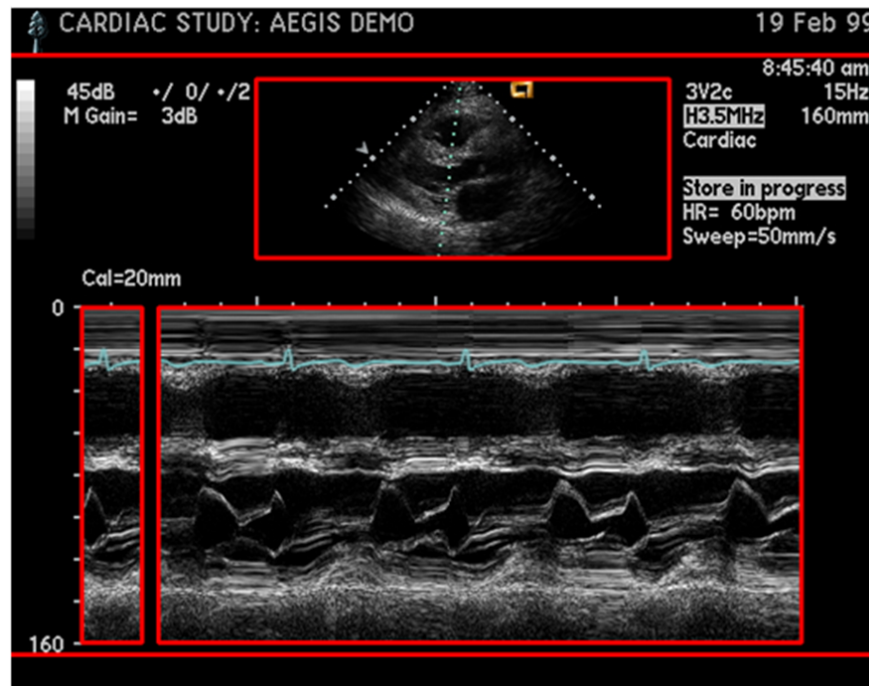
Calibration regions for the M mode of an echocardiogram acquired with an Agilent device.
